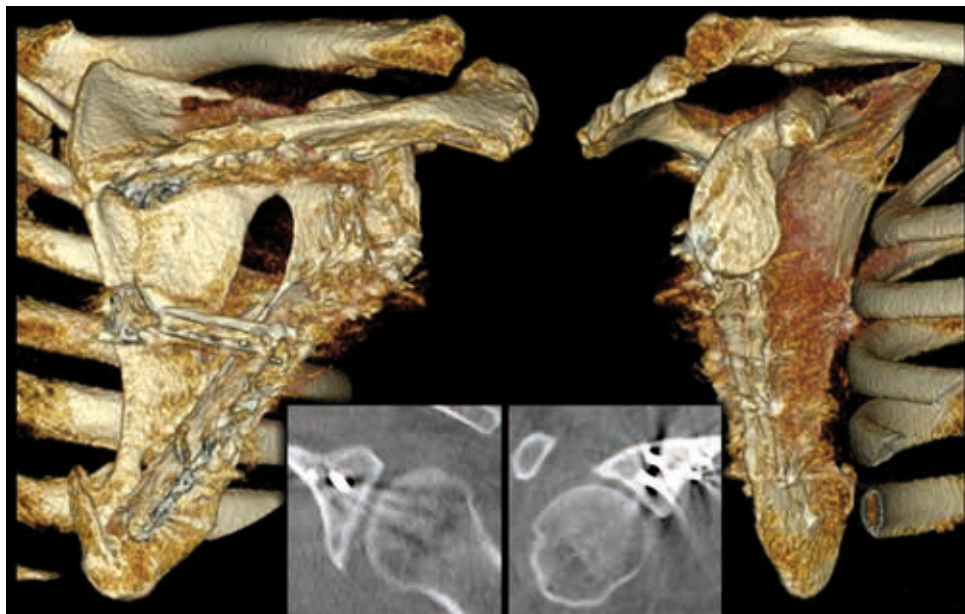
Follow-up CT scan 2.5 years postoperatively.
